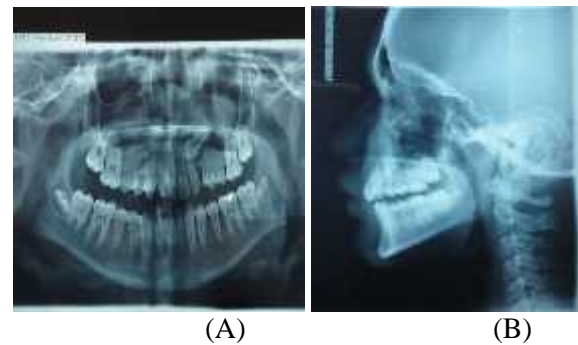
Pretreatment radiograph OPG (A), Lateral Cephalometry (B).
